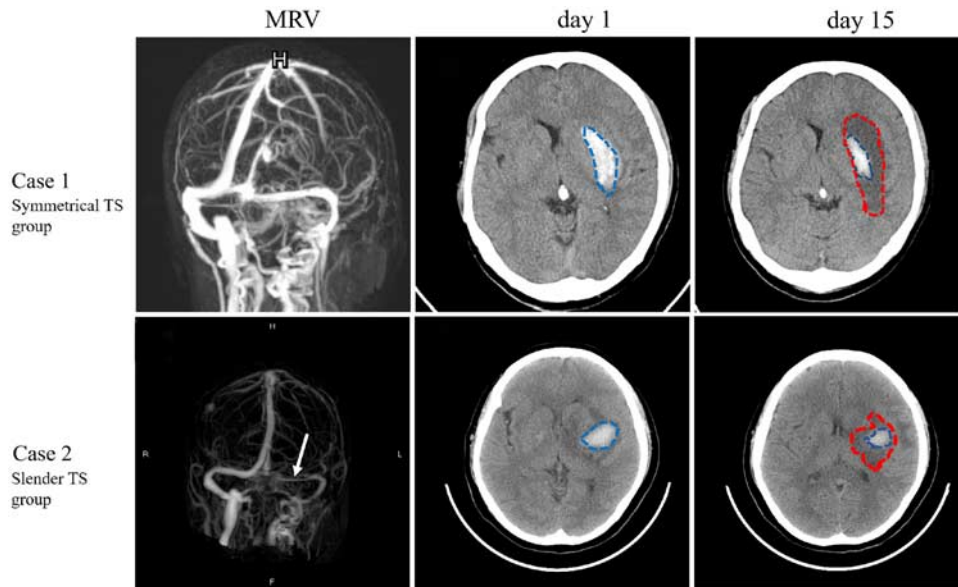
Region of interest analyses. Hematoma (blue) and visible perihematoma edema (red) volumes shrank on both noncontrast computed tomography and CT perfusion sequences. Ventricles were excluded. White arrow pointed to the slender transverse sinus on the left side. MRV indicates magnetic resonance venography; TS, transverse sinus.
